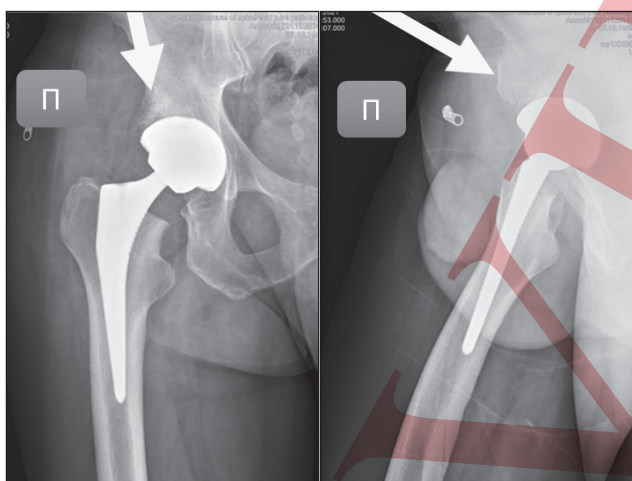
X-ray images of the right hip joint on the 30th day after hip replacement surgery and bone defect reconstruction
